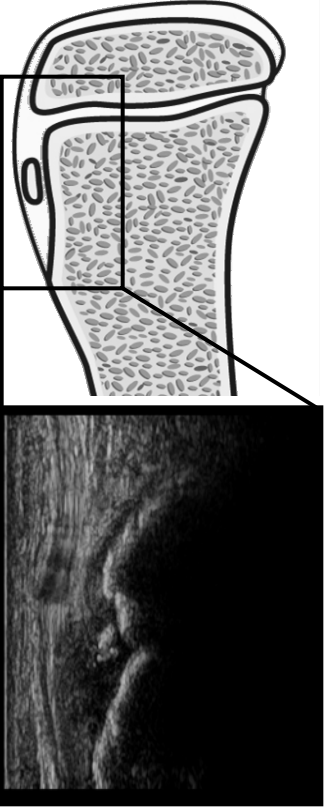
New ultrasonographic classification of tibial tuberosity development.
